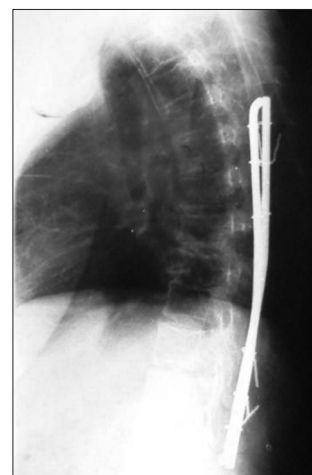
Thoracic spine X-ray [lateral view] of a patient who had thoracic laminectomy for an extradural spinal lesion followed by spinal stabilization with vertical strut and wire (Adeolu *et al.* technique^[7])
